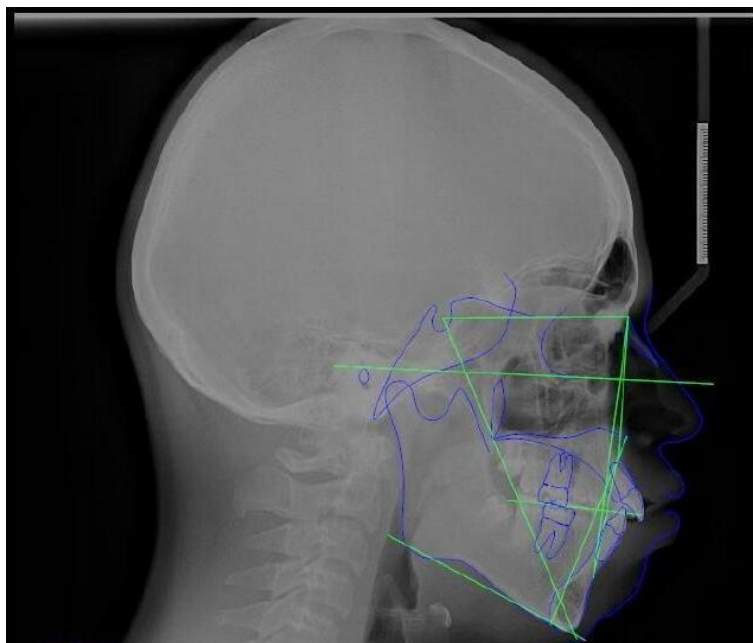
Posttreatment lateral cephalometric radiograph with tracing (T1), showing the advanced maxillary position relative to Fig. 3.
